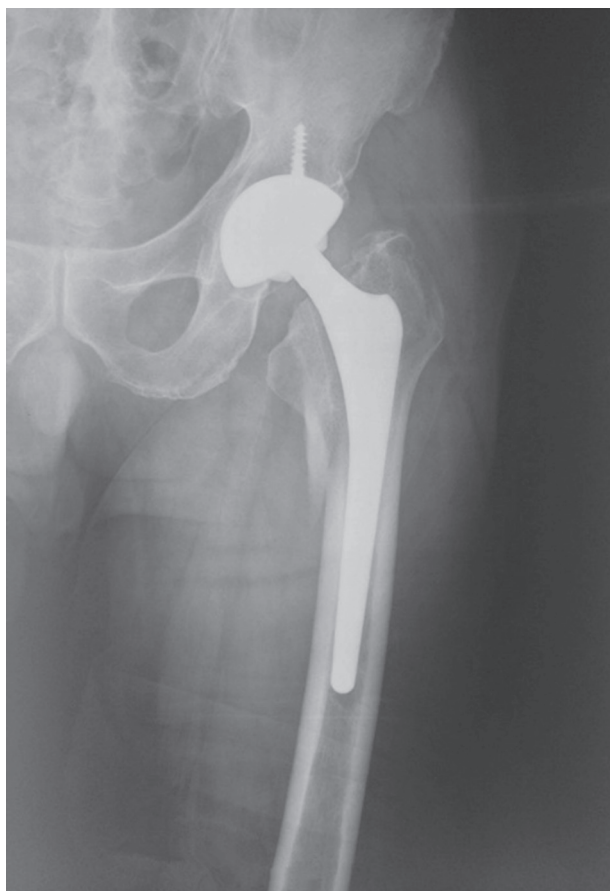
Anteroposterior radiograph of the left hip and proximal femur showing a pseudo A type periprosthetic fracture, but it's really a B2 type periprosthetic fracture. Fractures of the lesser trochanter as well as the greater trochanter, the stem is loose but there is adequate bone stock.
